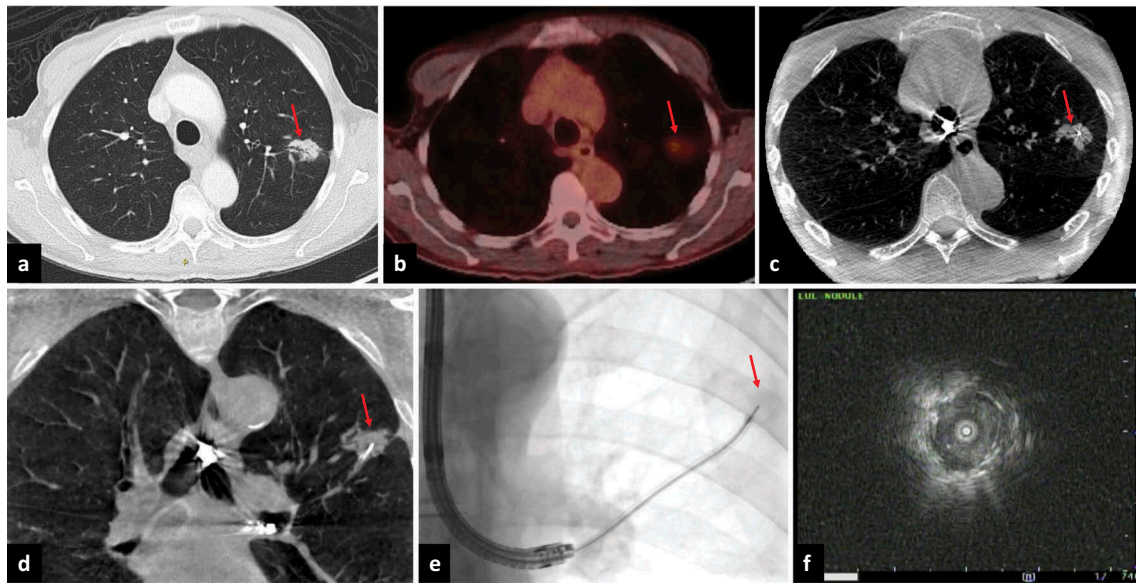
Cone-beam CT for electromagnetic navigation-free targeting of a peripheral lung nodule. A 71-year-old man with a left upper-lobe nodule measuring 2.6×1.9 cm on CT (a, arrow) with a maximum standardized uptake value of 2.9 on PET-CT (b, arrow). Diagnostic bronchoscopy was performed using cone-beam CT (c and d) and two-dimensional fluoroscopy (e) to confirm localization of the target lesion (arrows) and obtain visual confirmation of the biopsy instrument within the nodule. The nodule was also visualized on radial endobronchial ultrasound (f) for additional confirmation. Cytology revealed non-small cell lung cancer.
